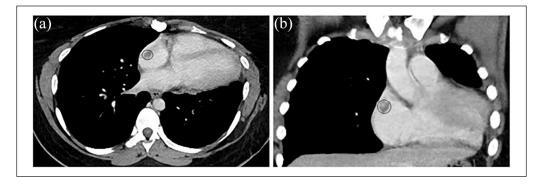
Computed tomography imaging (CT) series: (a) Transverse view demonstrating the encircled residual thrombus burden, which has been considerably attenuated by direct oral anticoagulation with rivaroxaban for 3 months and (b) sagittal view again demonstrating the residual thrombus burden.
